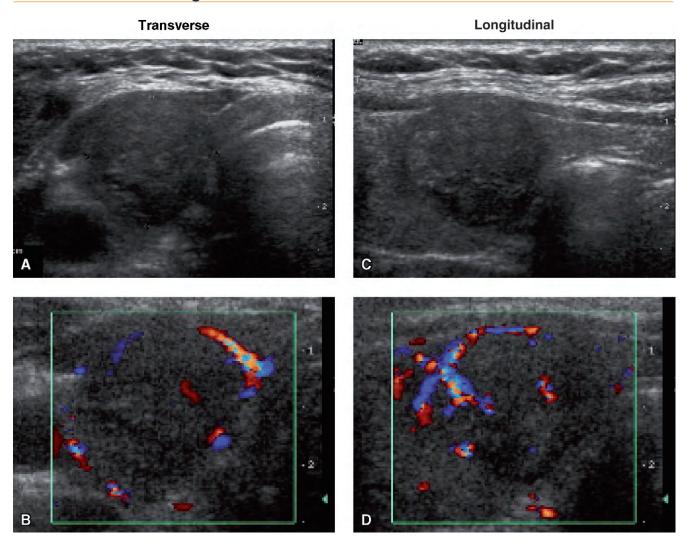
Ultrasound of follicular adenoma in the right lobe. A, Transverse, 15 x 15 mm. B, Color Doppler, transverse. C, Longitudinal, sagittal diameter: 17 mm. D, Color Doppler, longitudinal.
